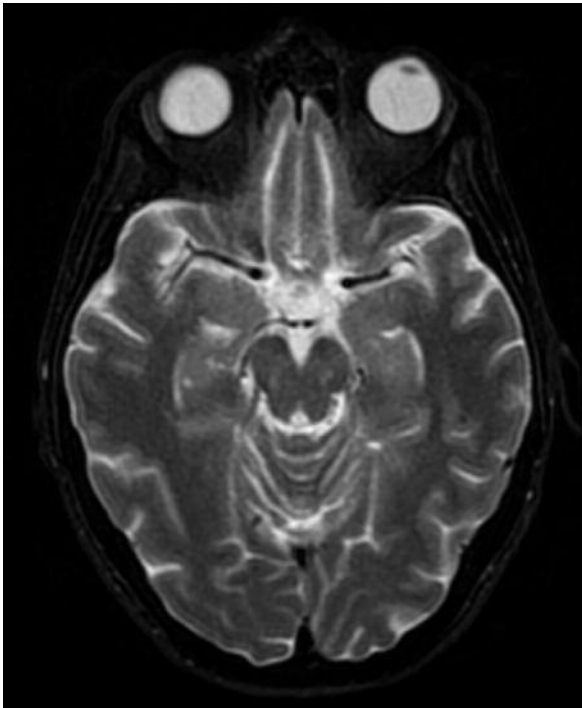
Brain MRI long TR and FLAIR images showing hyper-intensity of both thalamic system and either the mamillary bodies as well as the white peri-aqueductal matter.
